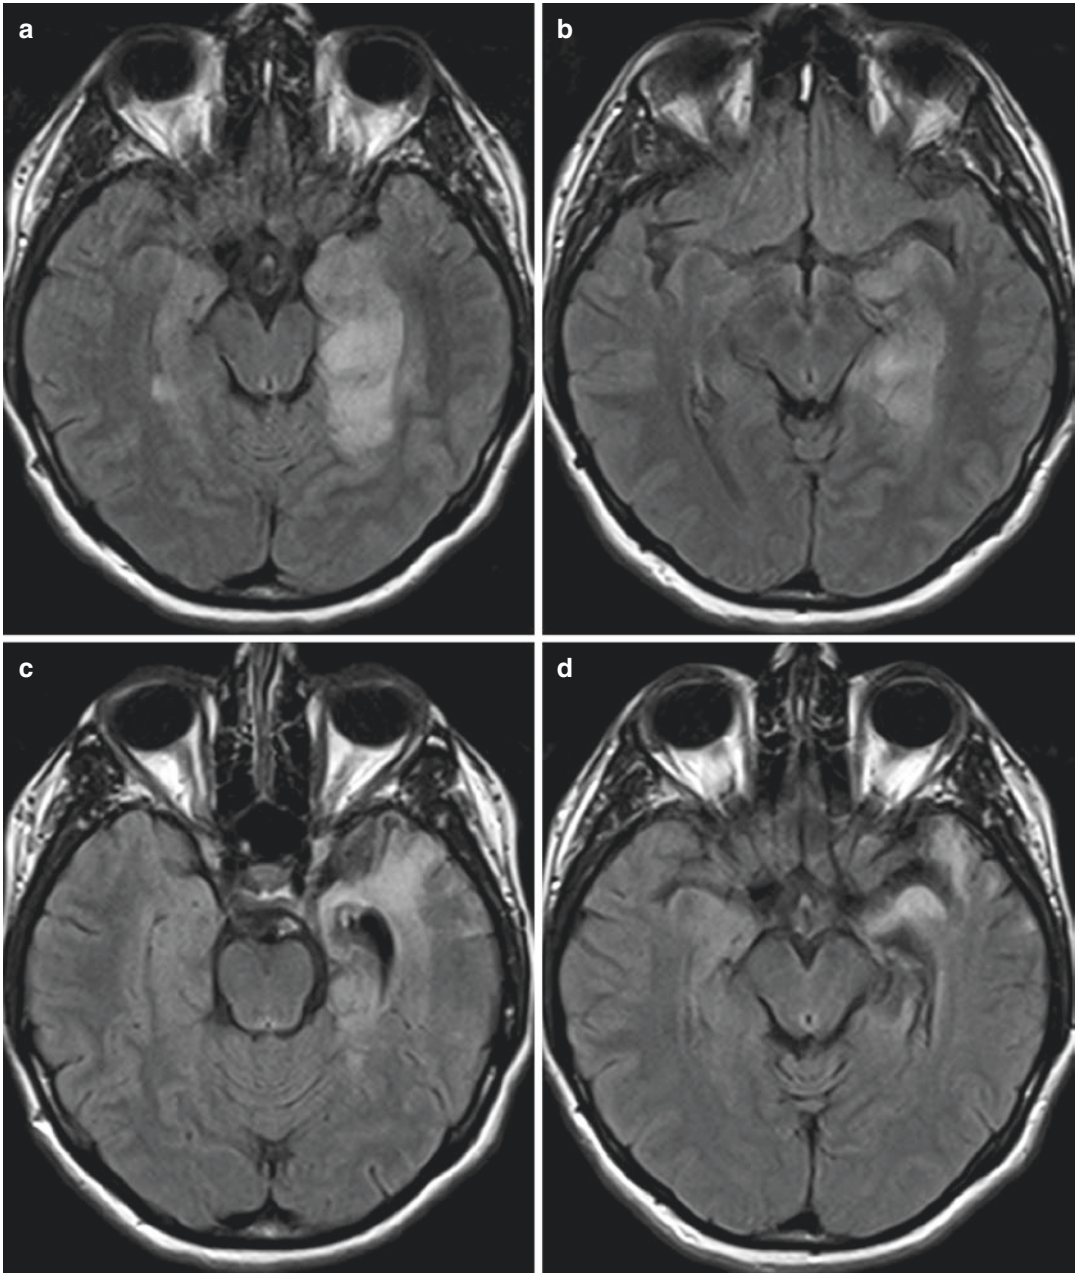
Herpes encephalitis. (a and b) FLAIR axial sections: presence of gyral swelling with indistinct gray-white interfaces in the left anterior medial temporal lobe, associated with a small hyperintense area in the right
